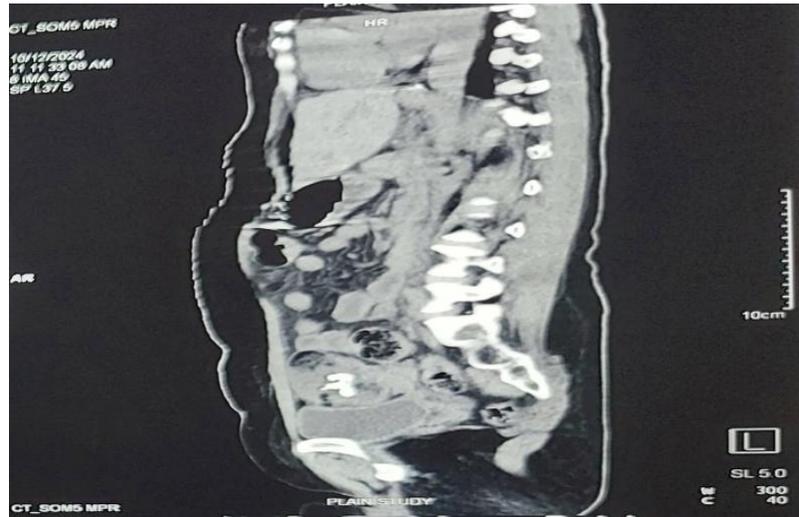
Sagittal median section of CT scan abdomen and pelvis shows nondependent low attenuation fat seen in the anterior abdominal wall, forming a fat fluid level.
